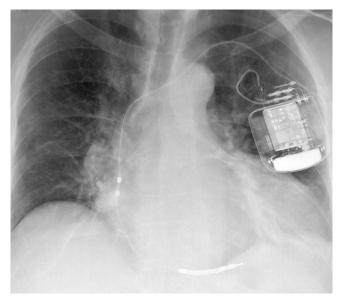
An X-ray image of an implanted Kainox VDD electrode connected to a Deikos A+ ICD (Biotronik, Germany).
